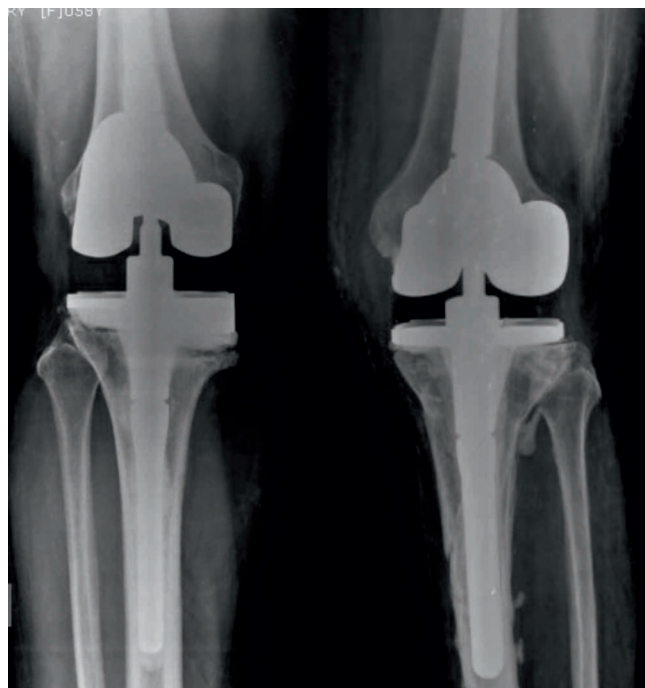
Postoperative radiographs of both knees following two-stage revision total knee arthroplasty.
